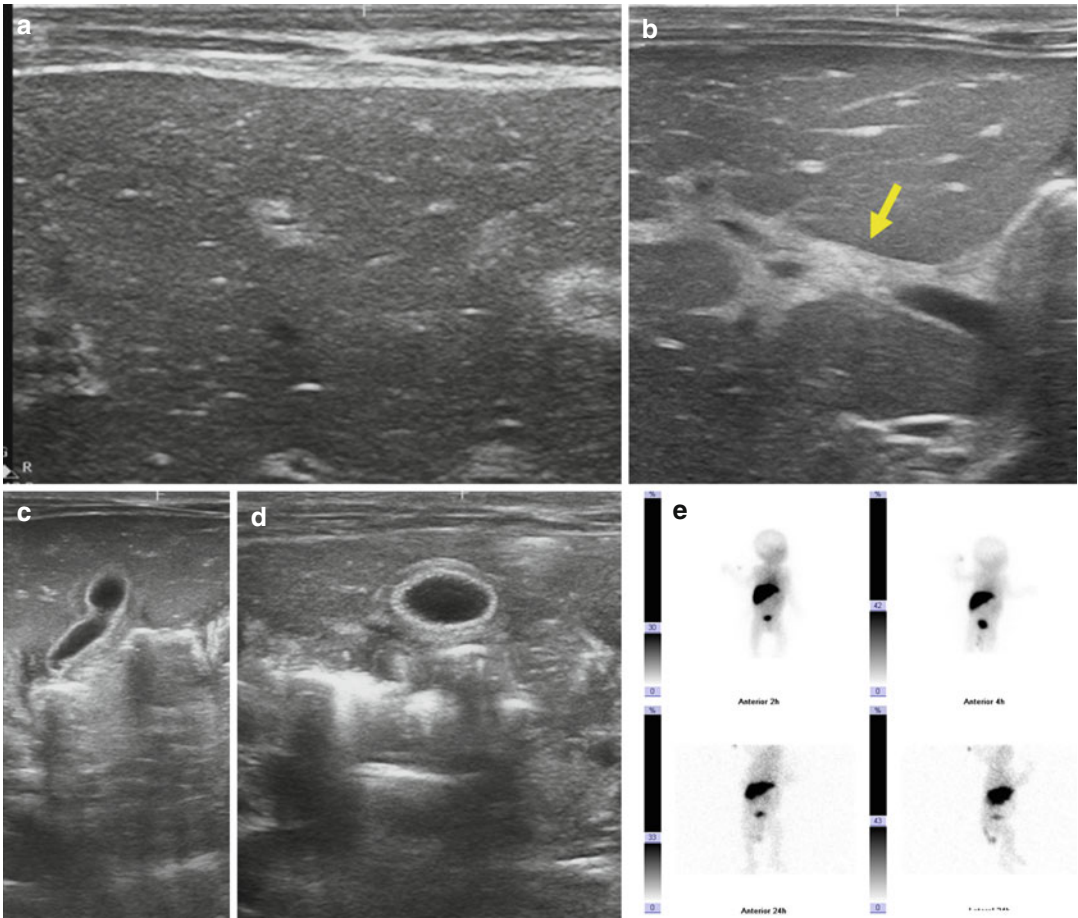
Sonographic scans show main features of BA diagnosis. (a) High-frequency ultrasound with linear probe is used to evaluate the hepatic parenchyma. Transverse scan shows the hepatic parenchyma inhomogeneous, with a marked increase in periportal echoes due to fibrosis. (b) TC sign. Triangular- or tube-shaped echogenic focus at the porta hepatis that follows the portal veins more than 4 mm in thickness (*arrow*) that anatomically
